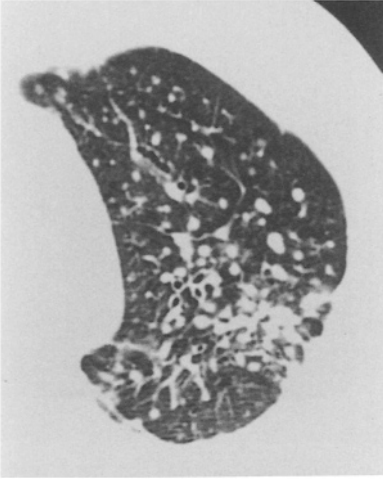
HRCT scan of silicosis. Nodules are predominantly posterior in distribution
